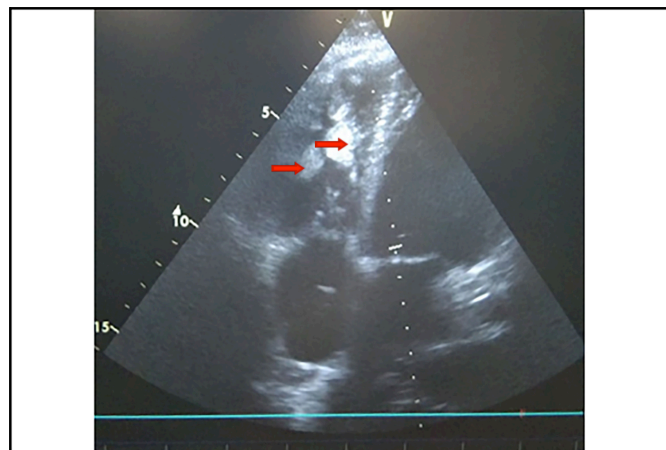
Echocardiography. Two clots were visualised in the right ventricle as indicated (arrows) measuring $2 \times 2 \text{ cm}$ and $1.5 \times 1.5 \text{ cm}$ each.
